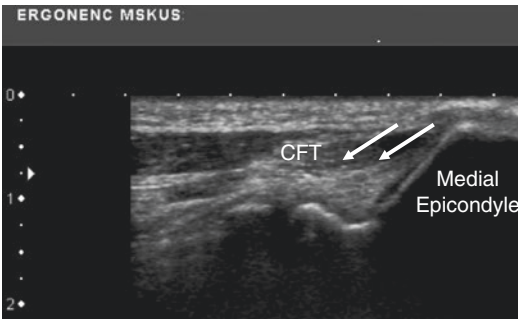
Long-axis sonogram of the common flexor tendon and medial epicondyle and ulnar collateral ligament (white arrows). The needle should be inserted distal to proximal with an in-plane approach to the transducer
